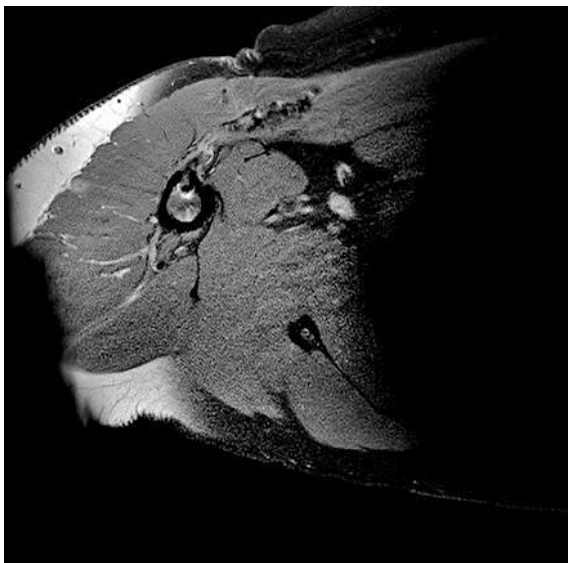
MRI Axial image presenting a healed pectoralis major tendon to the humerus with the DX Reinforcement Matrix attached
